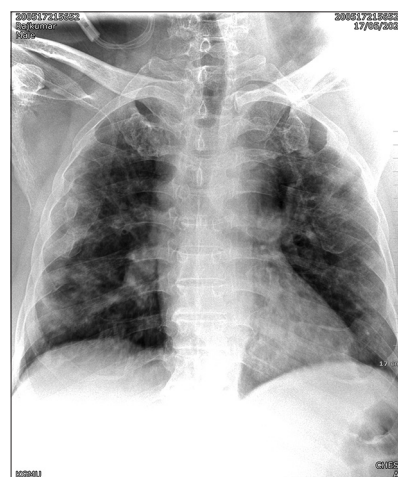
X-ray chest shows bilateral peripheral lung field ground glass opacities predominantly in mid and lower lung zones. Costophrenic angles of both side are clear
